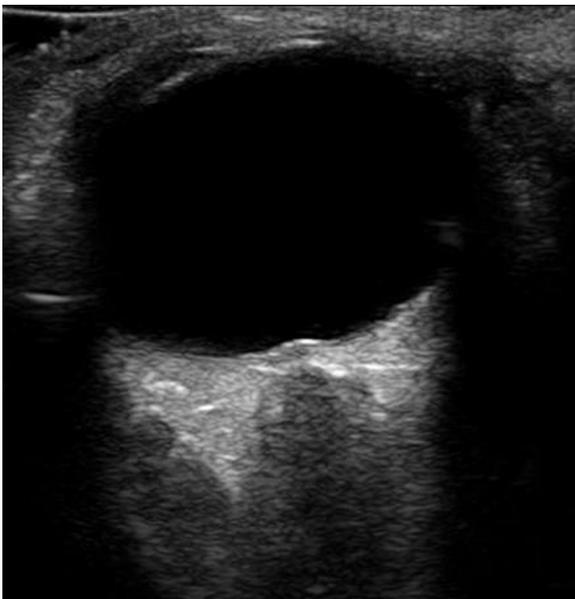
Ultrasound of the left orbit in transverse axis demonstrating optic disc elevation with a normal optic nerve sheath diameter, known as pseudopapilledema.
